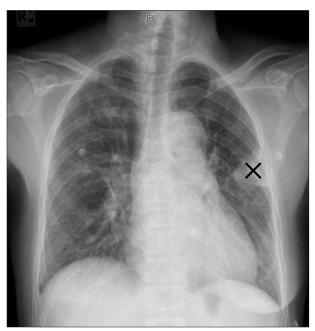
Chest radiograph showing a peripheral wedge shaped opacity in the left mid zone (Hampton's hump; X)
